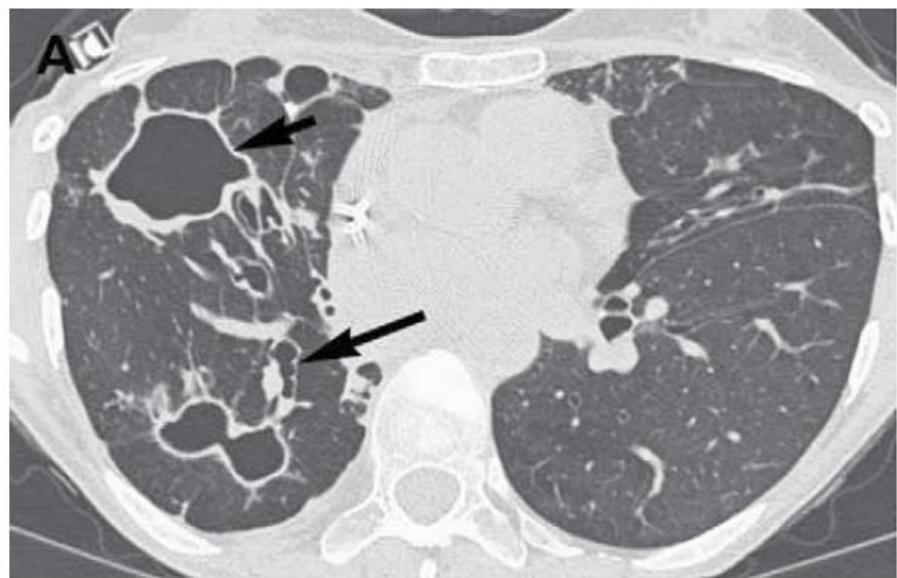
CT findings of varicose and cystic bronchiectasis. CT images from the same patient as in [Fig. 6](#) show a more severe form of bronchiectasis, where both varicose (*long arrow*) and cystic (*short arrow*) bronchiectasis is present (A). In varicose bronchiectasis, the bronchial lumen has a beaded appearance and nodular wall thickening is seen (arrowhead) (B).
